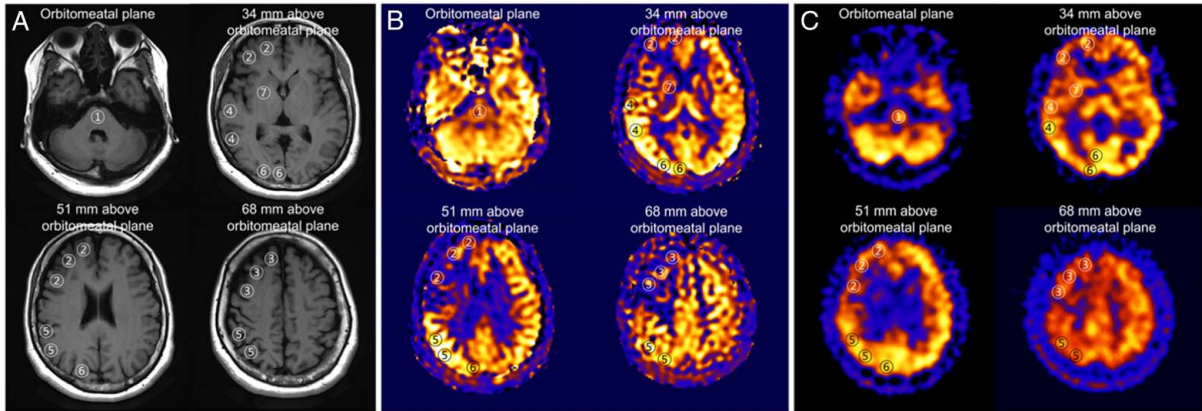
Regions of interest (ROIs) in each brain slice (orbitomeatal plane, orbitomeatal plane above 34 mm, orbitomeatal plane above 51 mm, and orbitomeatal plane above 68 mm). (A) T1 image; (B) ASL-MRI image; (C) SPECT image. 1 = pons, 2 = low frontal cortex, 3 = high frontal cortex, 4 = temporal cortex, 5 = parietal cortex, 6 = occipital cortex, and 7 = basal ganglia. ASL indicates arterial spin-labeling; MRI, magnetic resonance imaging; SPECT, single-photon emission computed tomography.
